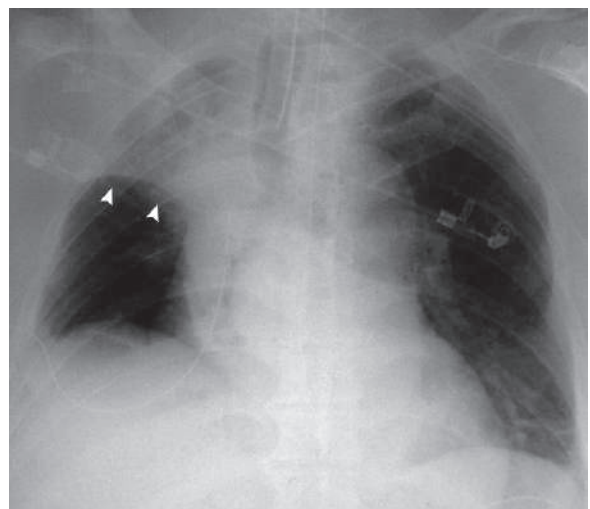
Posteroanterior plain chest radiographs show right upper lobe (RUL) atelectasis bounded inferiorly by the transverse fissure (arrowheads)
